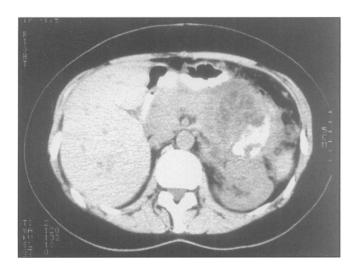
CT scan demonstrating a mucinous cystadenocarcinoma of the pancreas. Note the solid components. The contrast material within the cyst is due to the previous surgical drainage (cystgastrostomy), following misinterpretation as a pseudocyst.
